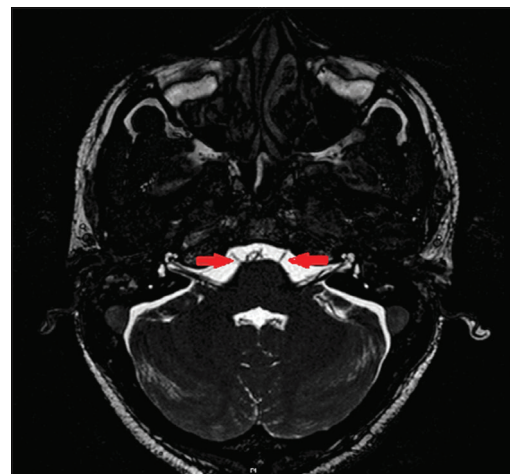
Magnetic resonance imaging showing B/L abducens nerve
